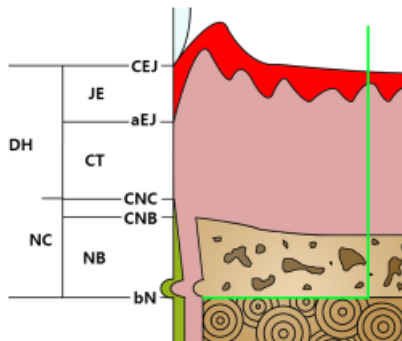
Landmarks/parameters used in the histometric analysis. The green template serves as a proxy for the defect site for estimation of bone regeneration area. CEJ, cemento-enamel junction; aEJ, apical epithelium junction; CNC, coronal new cementum; CNB, coronal new bone; bN, base notch; JE, junctional epithelium; CT, connective tissue attachment; NB, new bone; NC, new cementum; DH, defect height.
